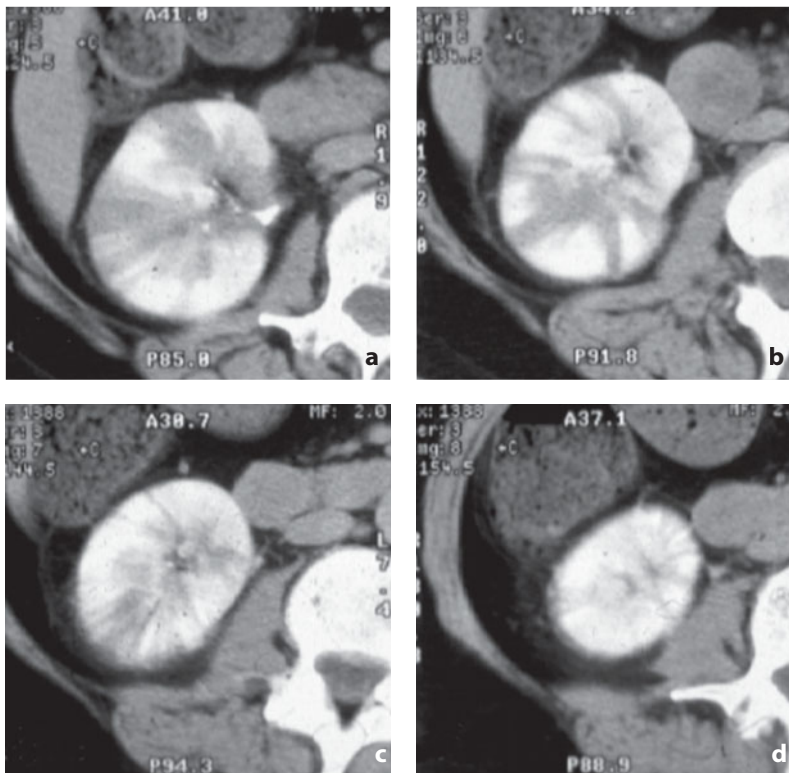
Contrast-enhanced CT. Acute diffuse pyelonephritis. a-d A striated nephrogram after contrast medium injection is visible, produced by the alternation of functioning tubules filled with contrast material and tubules clogged with leukocytes. The images also show hypoattenuating wedge-shaped areas resulting from edema and vasospasm (a, b)
